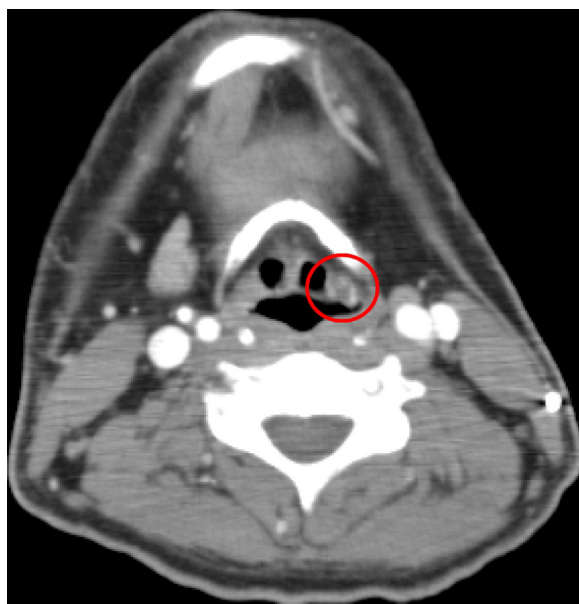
Computed tomography revealing a nodule approximately 10 mm in size on the left side of the false vocal cord (circled). Swelling of lymph nodes was not apparent.
